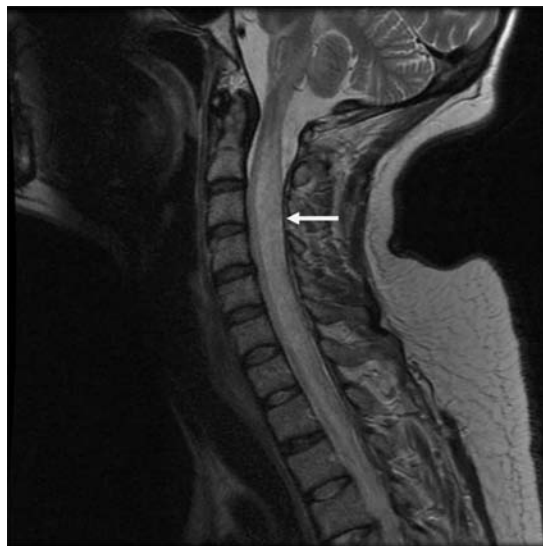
MRI of the patient's cervical cord. The T2 sequence demonstrated severe cord swelling suggestive of cord infarction.
